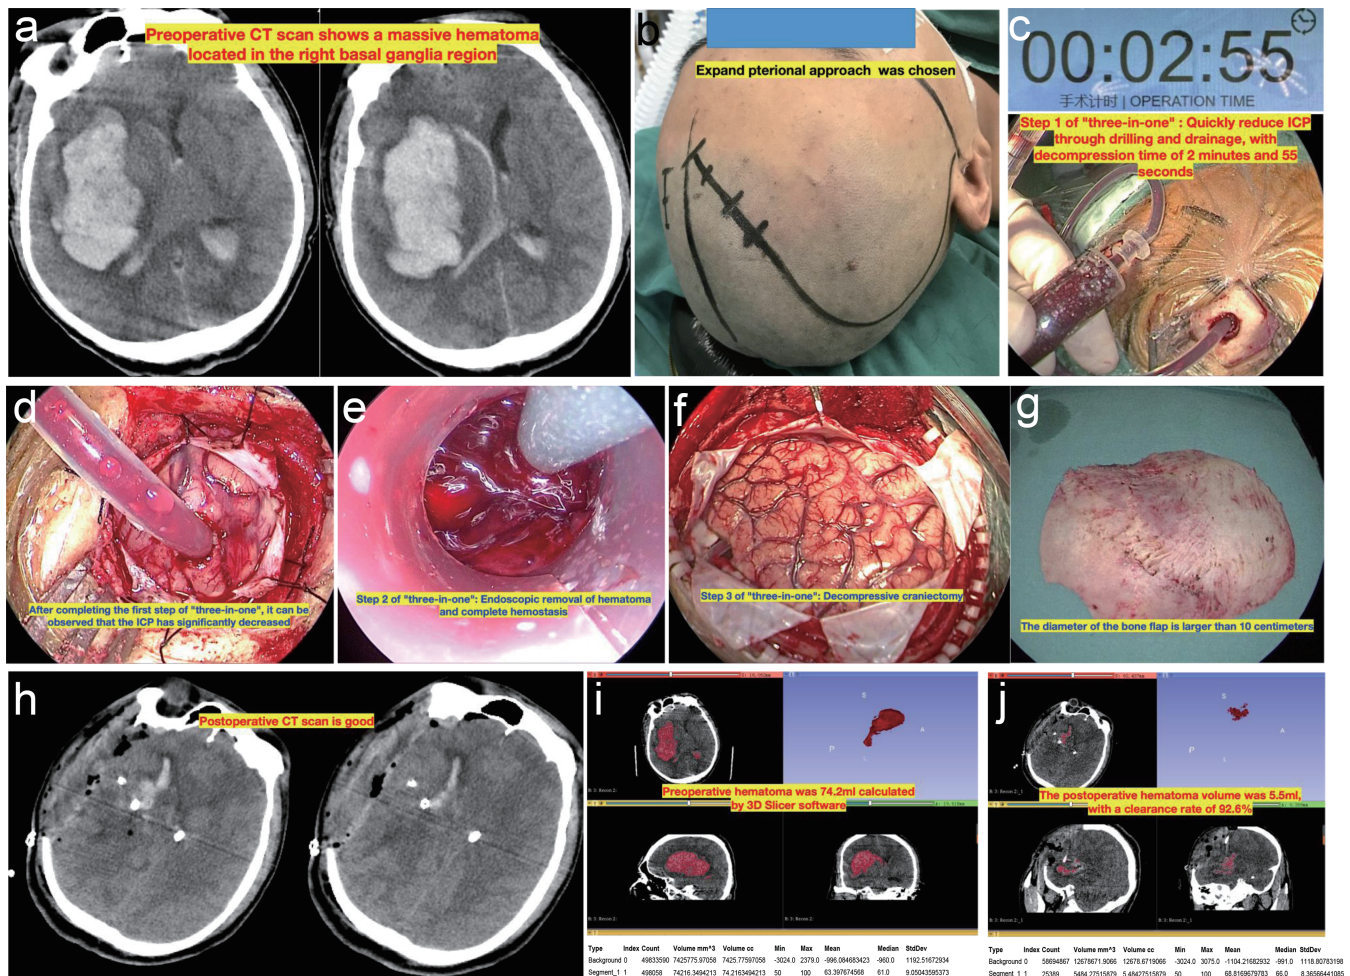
The three-in-one surgical strategy for large hematoma volume. (a) Preoperative non-contrast axial CT image demonstrating a massive hypertensive hematoma in the right basal ganglia region with significant mass effect and midline shift. (b) An expanded pterional approach was chosen. (c) ICP was quickly reduced through drilling and drainage, with a decompression time of 2 min and 55 s (defined as the interval from skin incision to the first observed reduction of intracranial pressure on the ICP monitor). (d) After completing the first step of “three-in-one”, it can be observed that the ICP has significantly decreased. (e) Endoscopic removal of the hematoma and complete hemostasis. (f) Decompressive craniectomy. (g) The diameter of the bone flap was larger than 10 cm. (h) Postoperative CT scan showing that the hematoma was removed satisfactorily. (i) Preoperative hematoma volume was 74.2 mL, calculated by 3D Slicer software. (j) The postoperative hematoma volume was 5.5 mL, with a clearance rate of 92.6%. CT, computed tomography; ICP, intracranial pressure.
